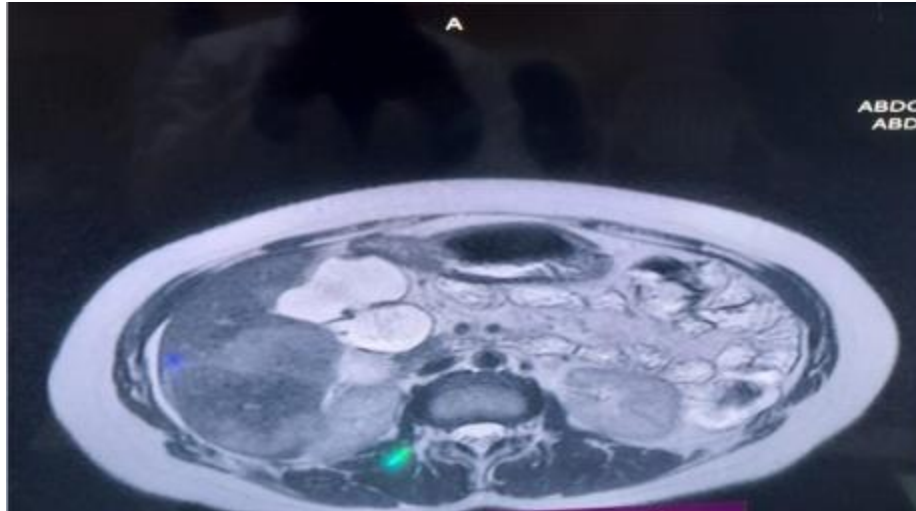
MRI showing the tumour in the liver.
